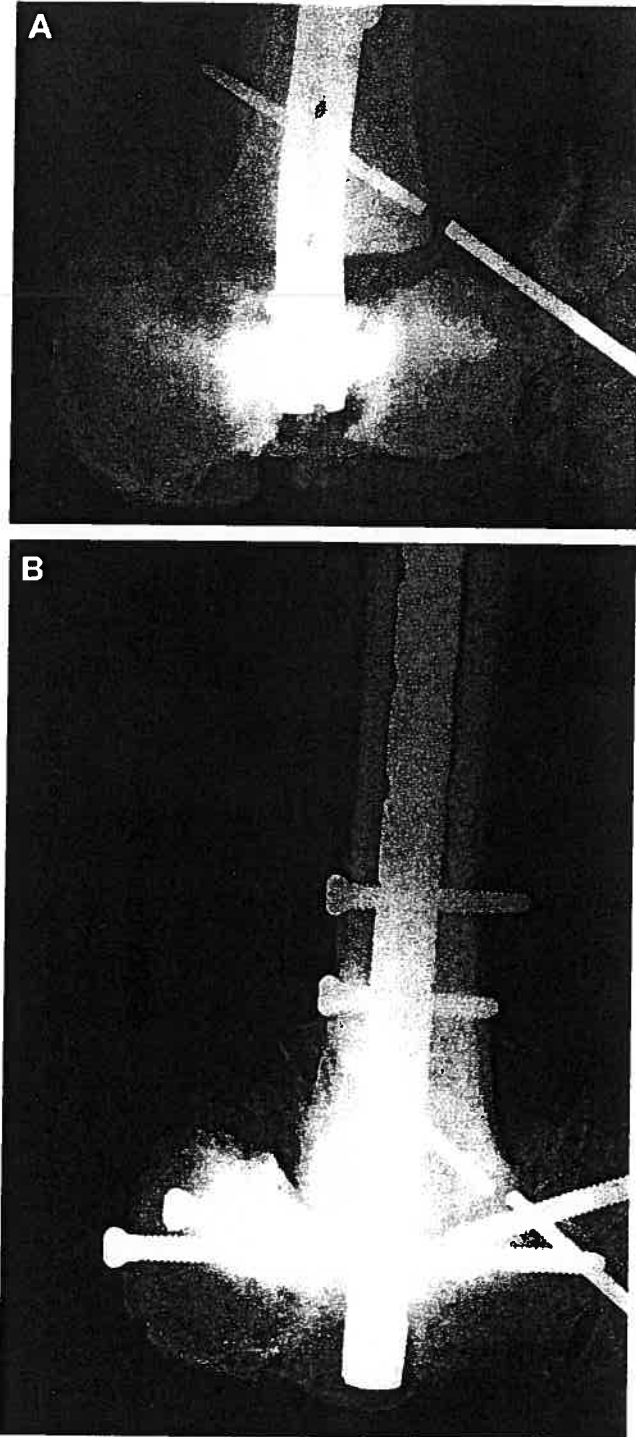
Fifty-eight-year-old, insulin-dependent, 90-kg, type-II diabetic. *A*, Poor distal fixation was achieved in this osteopenic calcaneus with excised talus. *B*, Radiographic fusion after surgical revision and protected weightbearing.
